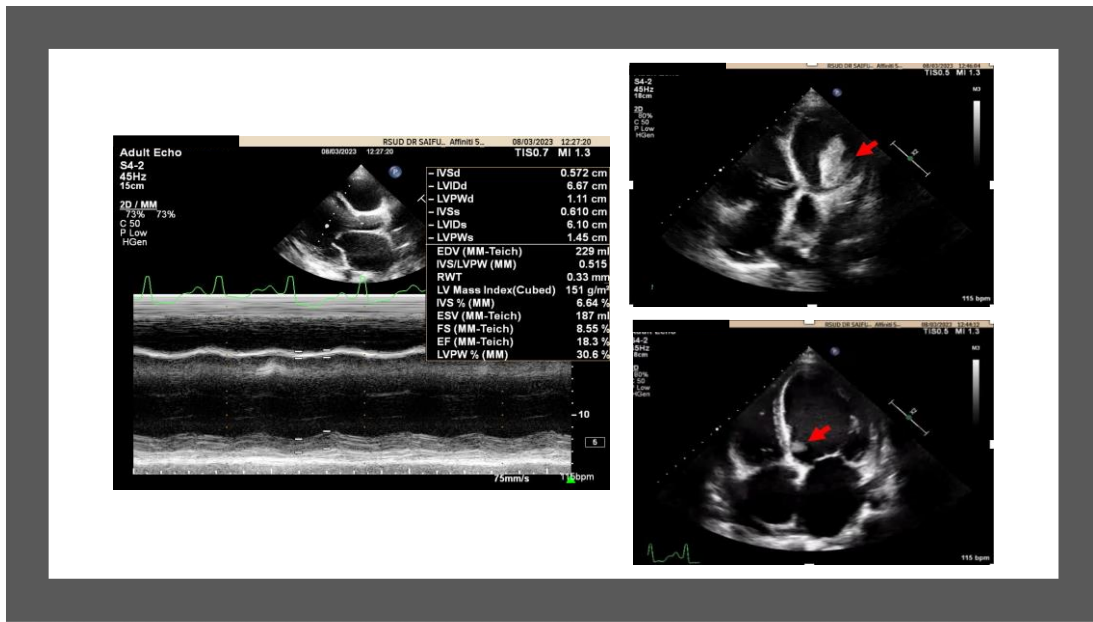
Transthoracic Echocardiography showed severe global LV systolic dysfunction and dilatation with mobile thrombus located at the basal inferoseptal region and massive thrombus measuring 4.64 cm x 1.83 cm is present at the basal mid anterolateral region
